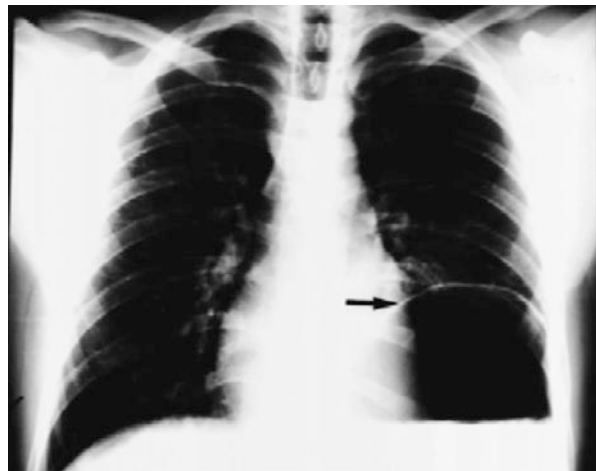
Chest X-ray revealing an elevated left hemidiaphragm (arrow), an early but nonspecific radiographic finding of diaphragmatic hernia. (Used with permission from Wolters Kluwer Health, Inc.; Bujanda et al. [17])
